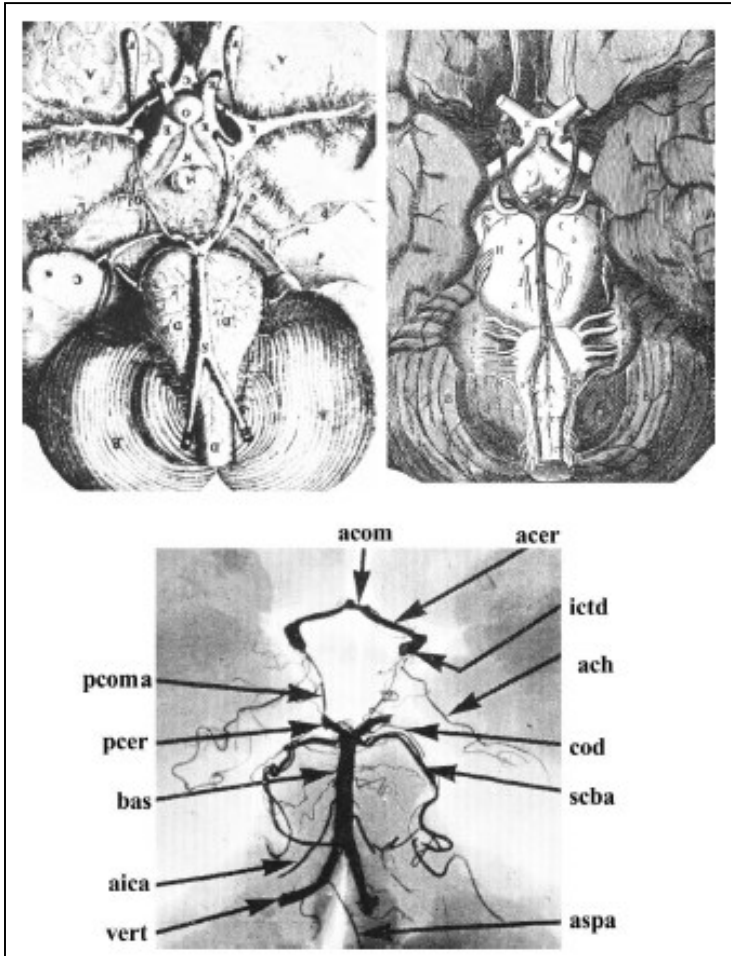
X-ray image obtained after injection of radioopaque material postmortem. Acom, anterior communicating; acer, anterior cerebral; ictd, internal carotid; ach, anterior choroidal; cod, choroidal-diencephalic; scba, superior cerebellar; aspa, anterior spinal; vert, vertebral; aica, anterior inferior cerebellar; bas, basilar; pcer, posterior cerebral; pcoma, posterior communicating.
